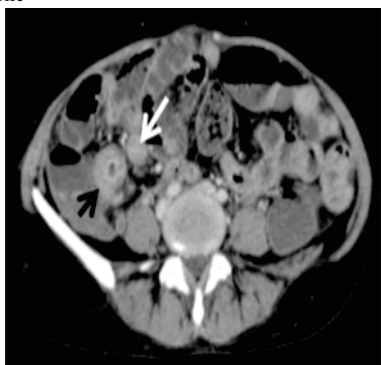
Axial CT image shows symmetric concentric mural thickening of terminal ileum (black arrow). There is also presence of regional homogeneous lymphadenopathy (white arrow)
